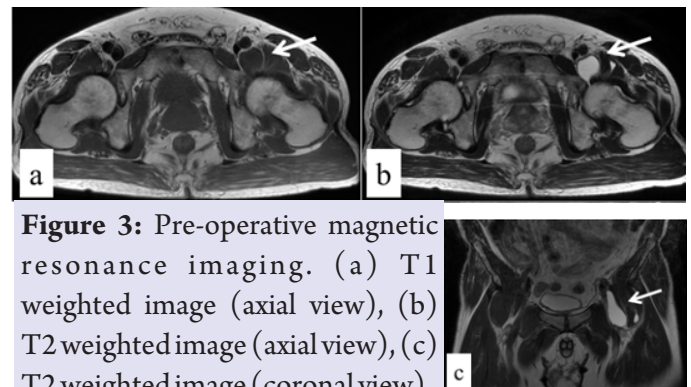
Pre-operative magnetic resonance imaging. (a) T1 weighted image (axial view), (b) T2 weighted image (axial view), (c) T2 weighted image (coronal view).
